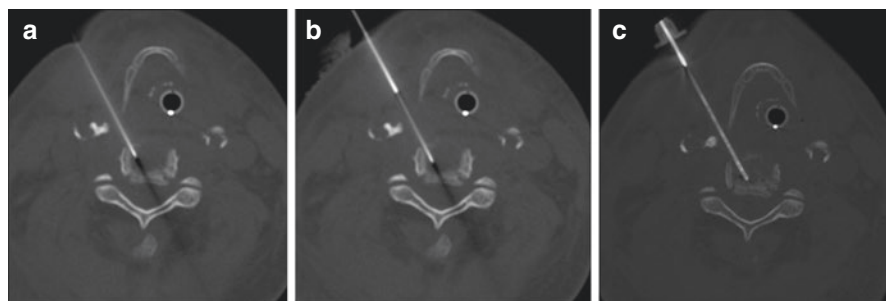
Anterolateral cervical spine access with CT guidance: a 22 G–17 cm spinal needle is inserted between the carotid artery (note calcification of the carotid bifurcation) and the trachea and advanced to the vertebral body medial to the uncinate process (a); the needle, once the hub is removed, serves as a guidewire to advance a larger caliber access cannula with Seldinger technique to the anterior third of the vertebral body (b and c)
